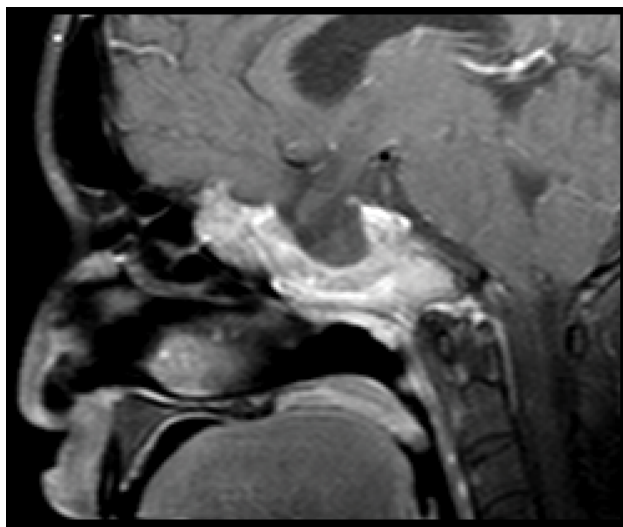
CT scan – Sagittal view.
